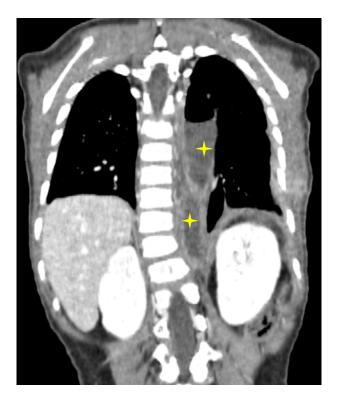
CT scan in injected coronal reconstruction showing two pleural collections, related to postoperative remodeling.
